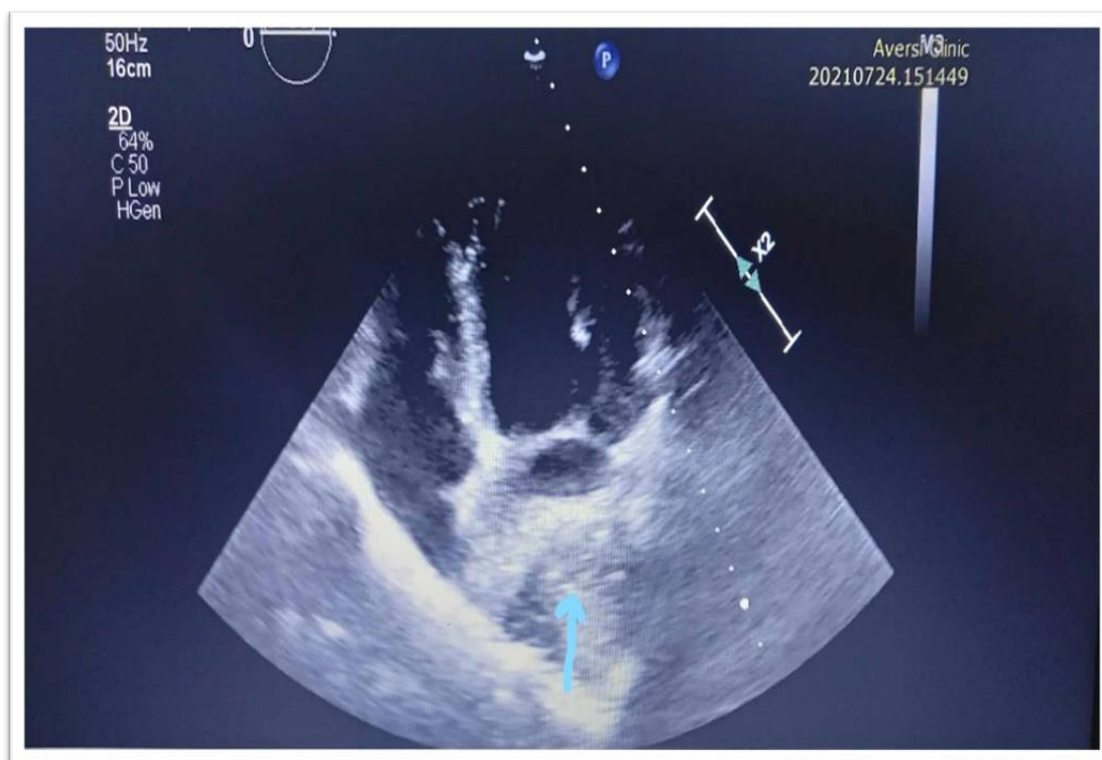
Apical 4-chamber view. Left atrial compression with extra cardiac structure (blue arrow)
